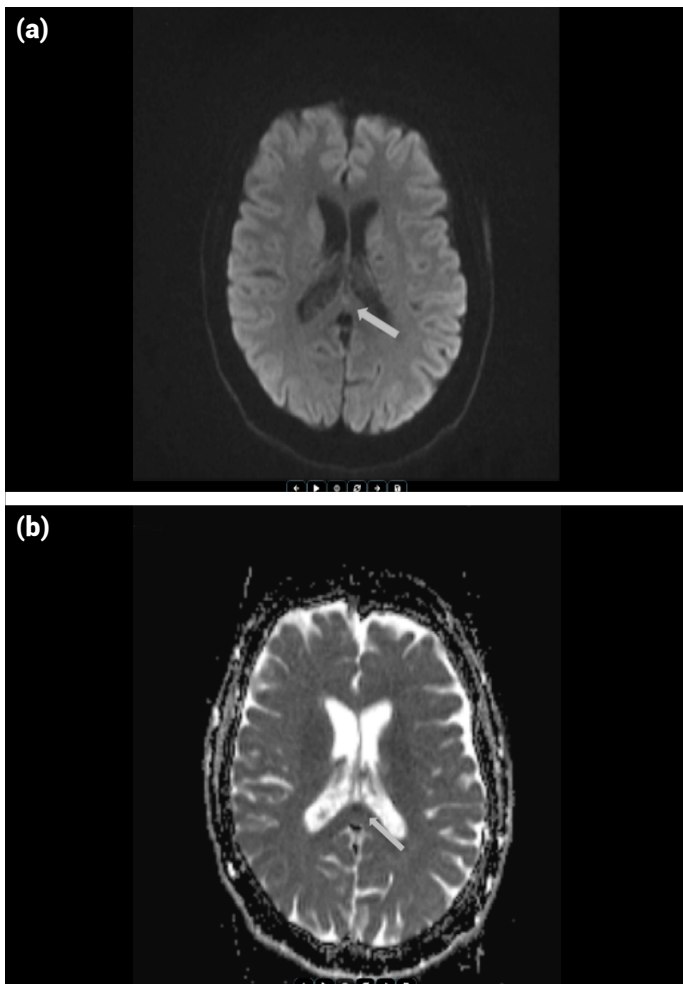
Case 3: (a) Acute diffusion restriction in the splenium of the CC on diffusion MRI showed by an arrow; (b) The corresponding area is showed hypo intensity on the ADC.
